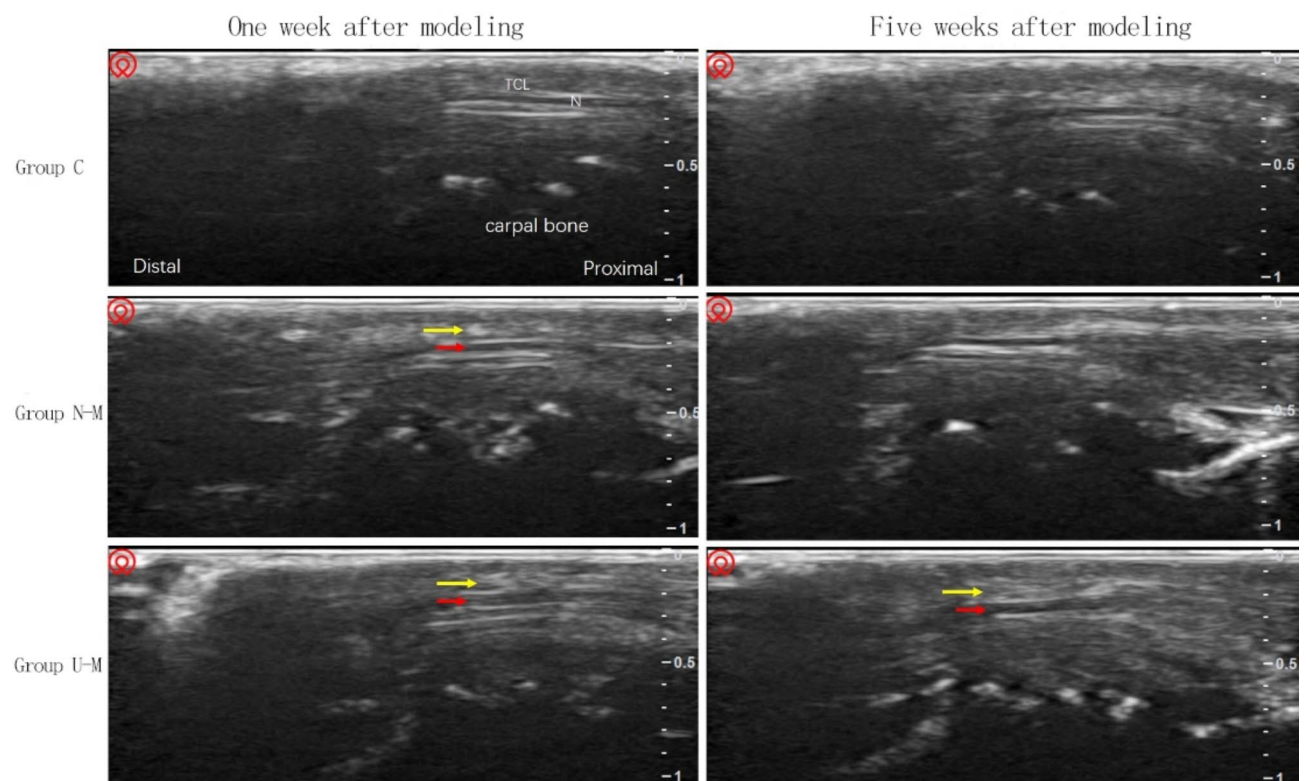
Longitudinal ultrasonic sections of carpal tunnel in each group at 1 week and 5 weeks after modeling.
